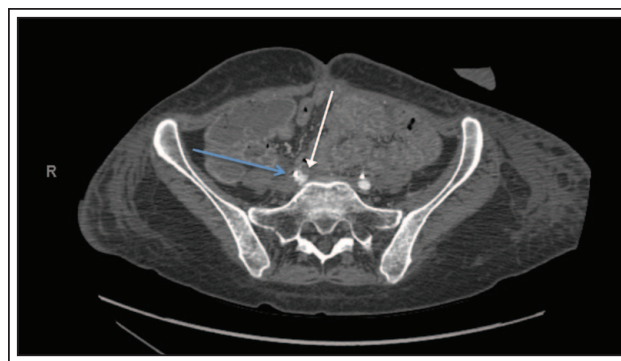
CT arteriogram shows contrast blush (arrow) where the right ureter (with indwelling stent, blue arrow) crosses the right common iliac artery.
